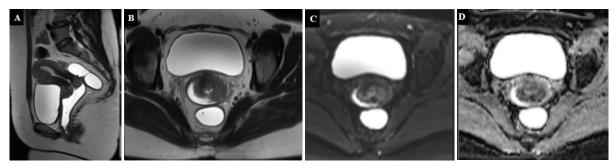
Pelvic MRI Examination of Case 7
